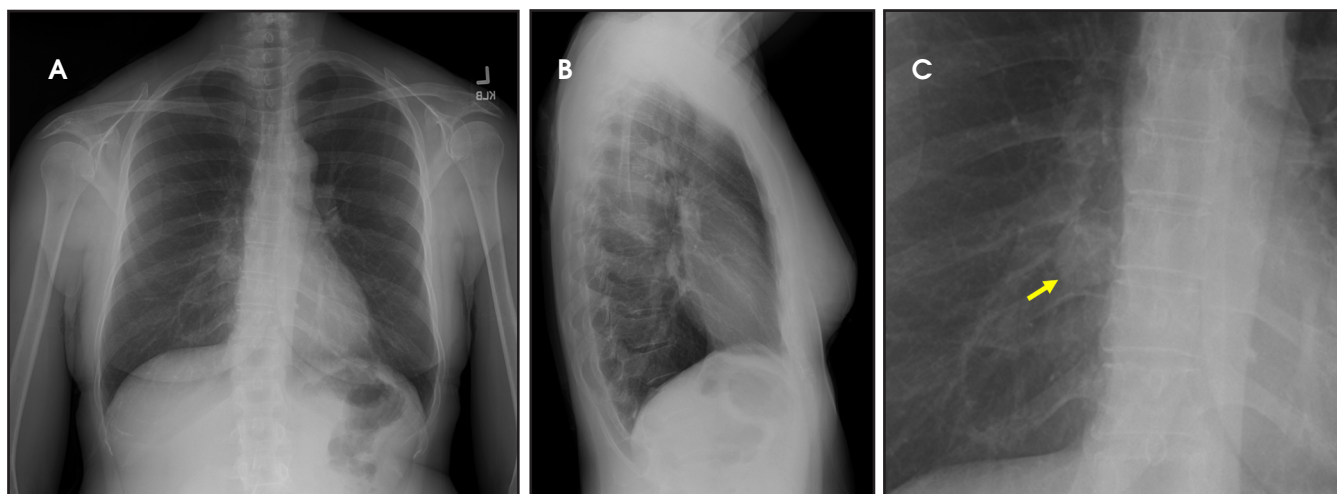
PA (Figure 1A) and lateral (Figure 1B) show a round mass in the medial right lower lobe. Detailed view (figure 1c) of the medial right lower lobe on the frontal radiograph confirms the round mass (arrow).
